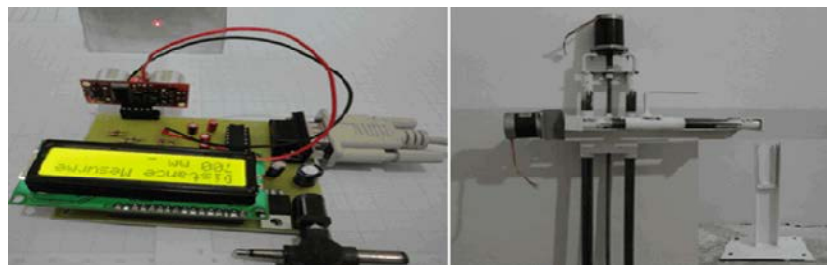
Hardware mover and the final sample distance meter ultrasonic device
